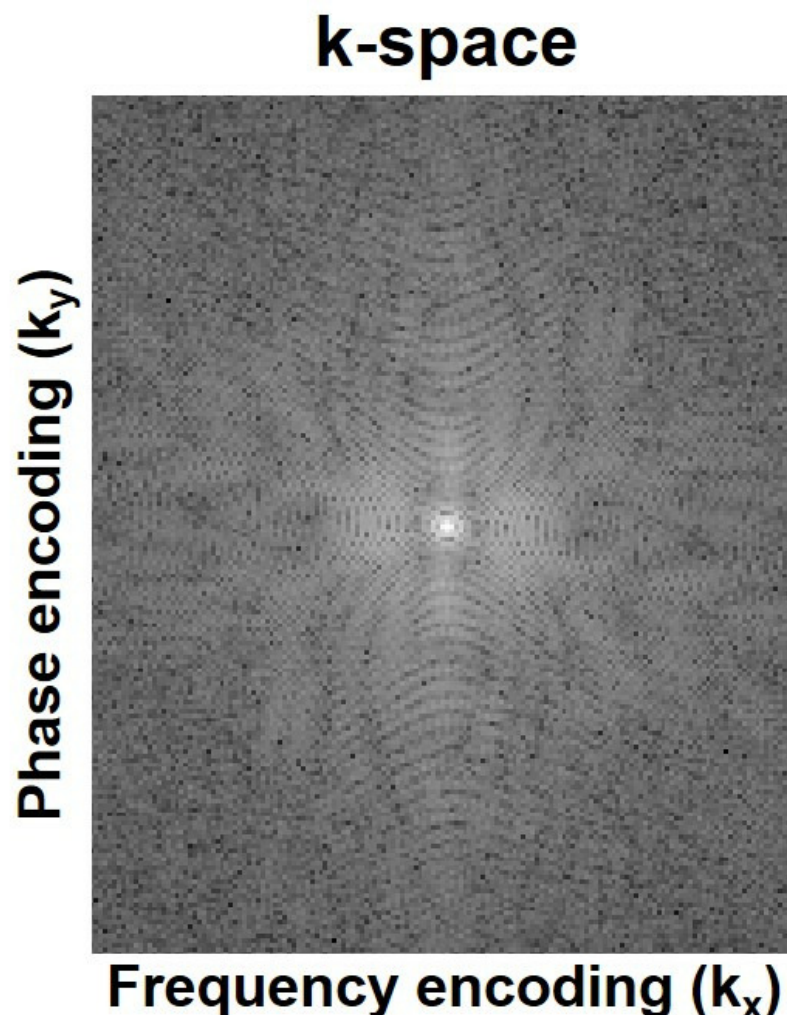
The *k-space* (i.e. original raw data) of a 2D brain MRI
